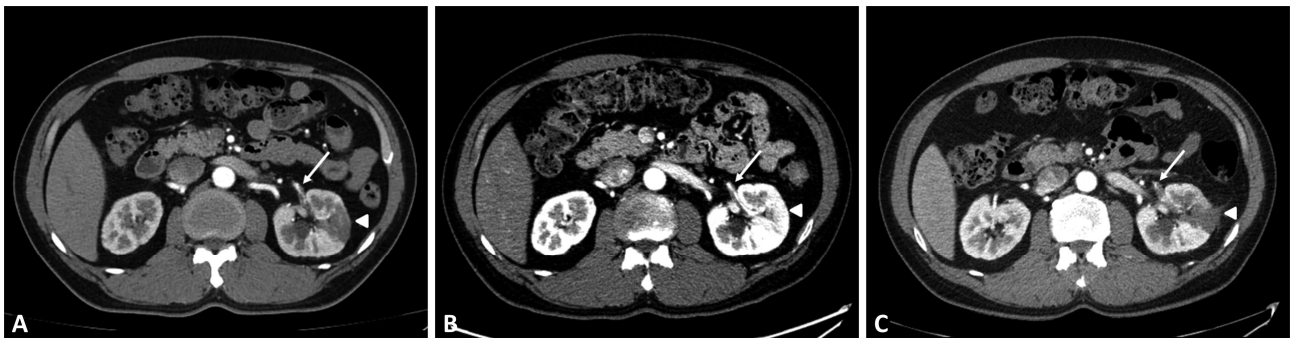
Serial transverse views of abdominal CT scans of the patient with renal infarction. (A) An abdominal CT scan at the local hospital revealed a perfusion defect in the left kidney (arrowhead); (B) The perfusion defect spontaneously resolved (arrowhead) in our emergency room; (C) The perfusion defect recurred (arrowhead) on the sixth day of hospitalization. A thrombus in the anterior segmental branch of the left renal artery (arrow) persisted on all serial abdominal CT scans.
